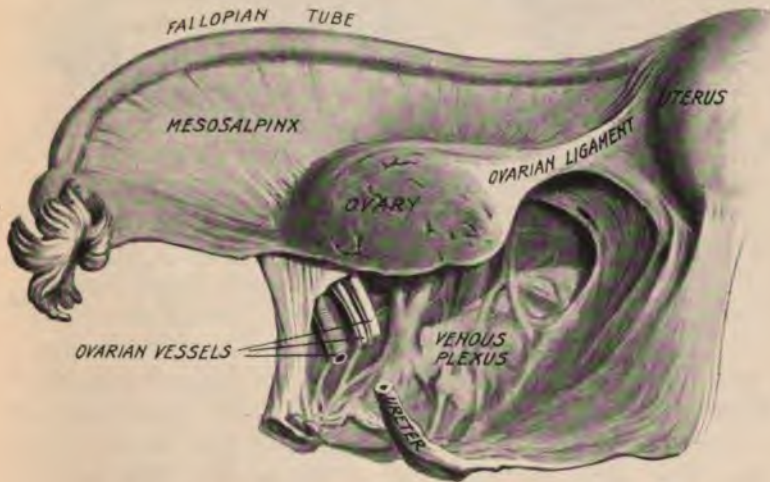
THE POSTERIOR ASPECT OF THE BROAD LIGAMENT
